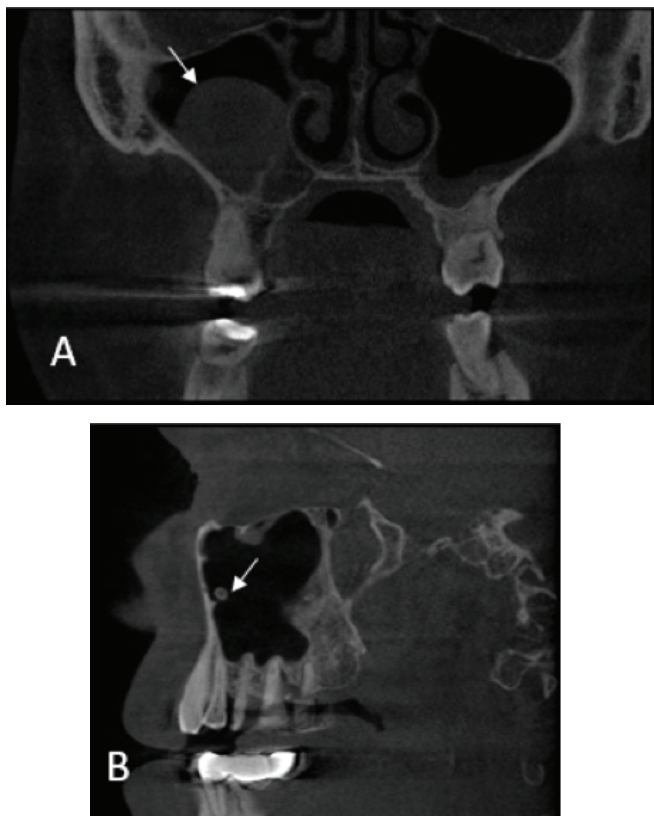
Various MS pathologies on CBCT images. A. Mucus retention cyst (white Arrow) B. Anthrolite (white Arrow)
